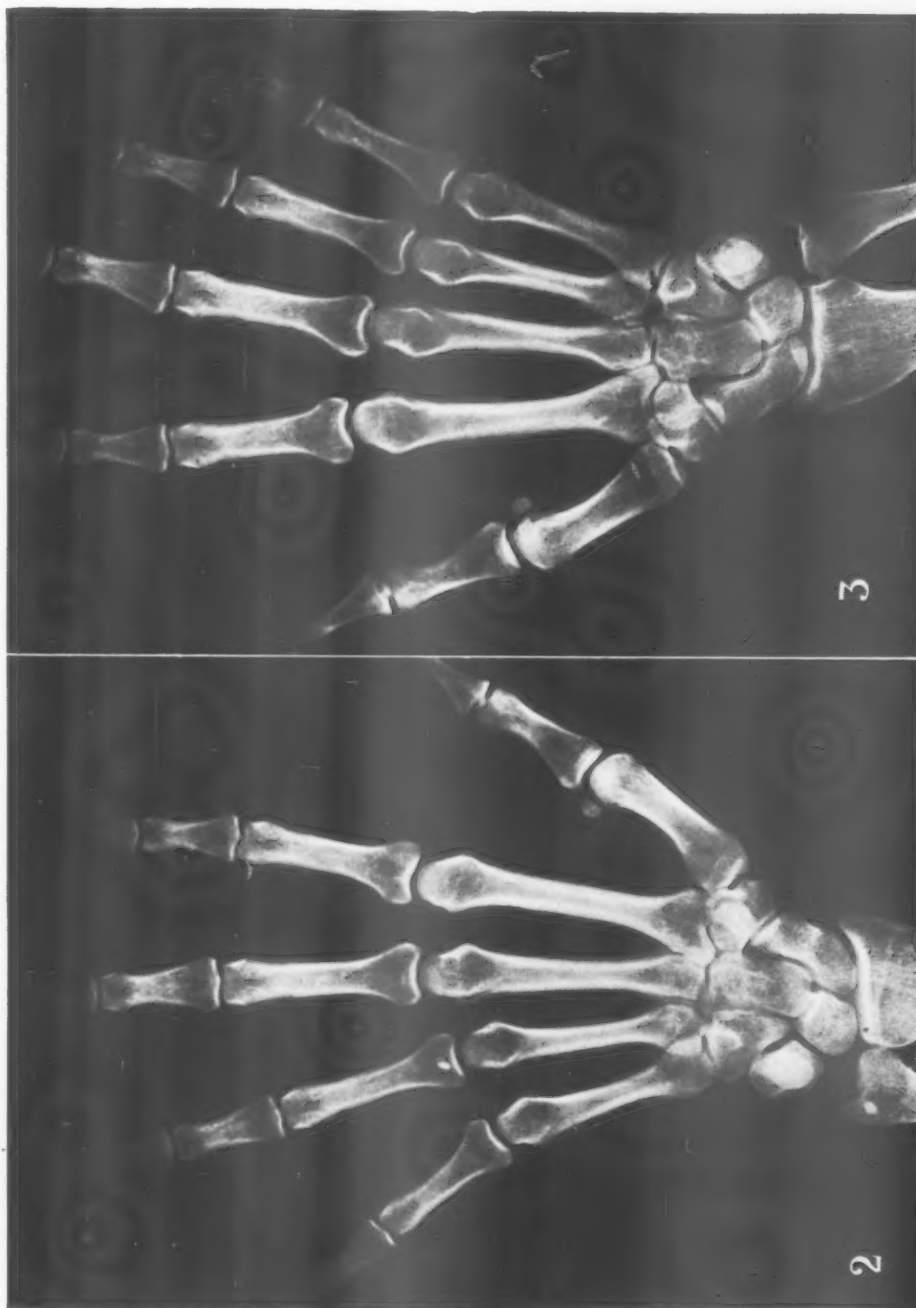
Radiograph of the left wrist and hand taken on June 25, 1947, showing no bone or soft-tissue abnormality.
